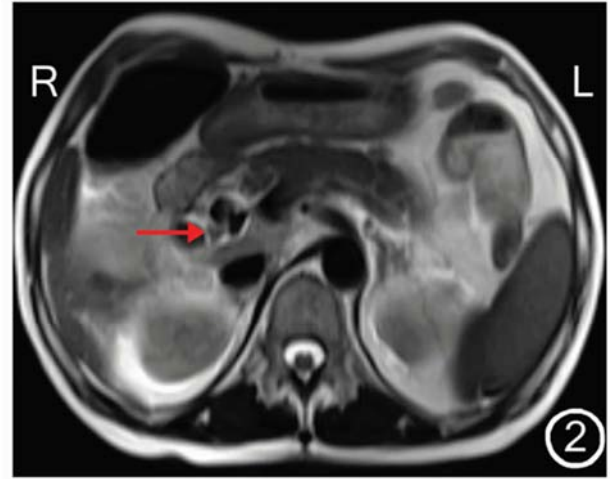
MRI examination showed multiple stones in the common bile duct and left hepatic duct combined with dilation of the intrahepatic and extrahepatic bile ducts and common bile duct (\rightarrow).
